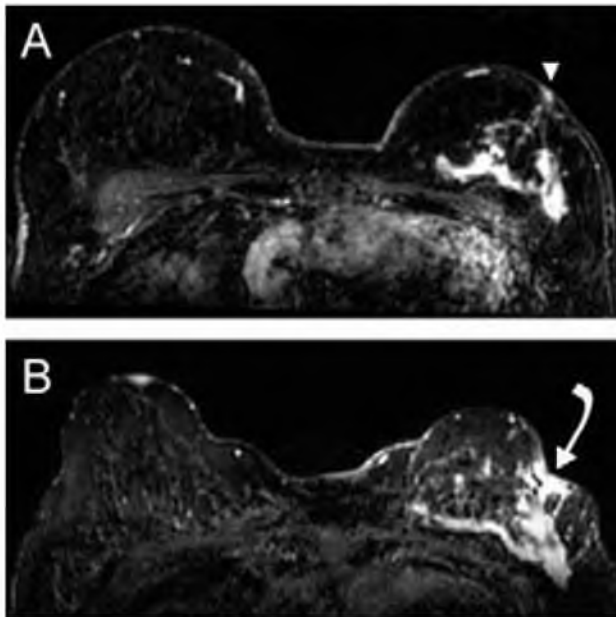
Two subtraction images of a 47 year old woman, who presented with a T4 ILC in the left breast. Initial assessment with MRI (A) shows a large diffuse growing tumor within the left breast with involvement of the skin (arrowhead). She was initially treated with neoadjuvant chemotherapy. The control MRI (B) unfortunately shows that the tumor did not respond well, but in fact had grown, while the patient became much thinner. Moreover the skin involvement worsened (curved arrow). Consequently salvage mastectomy was performed.
